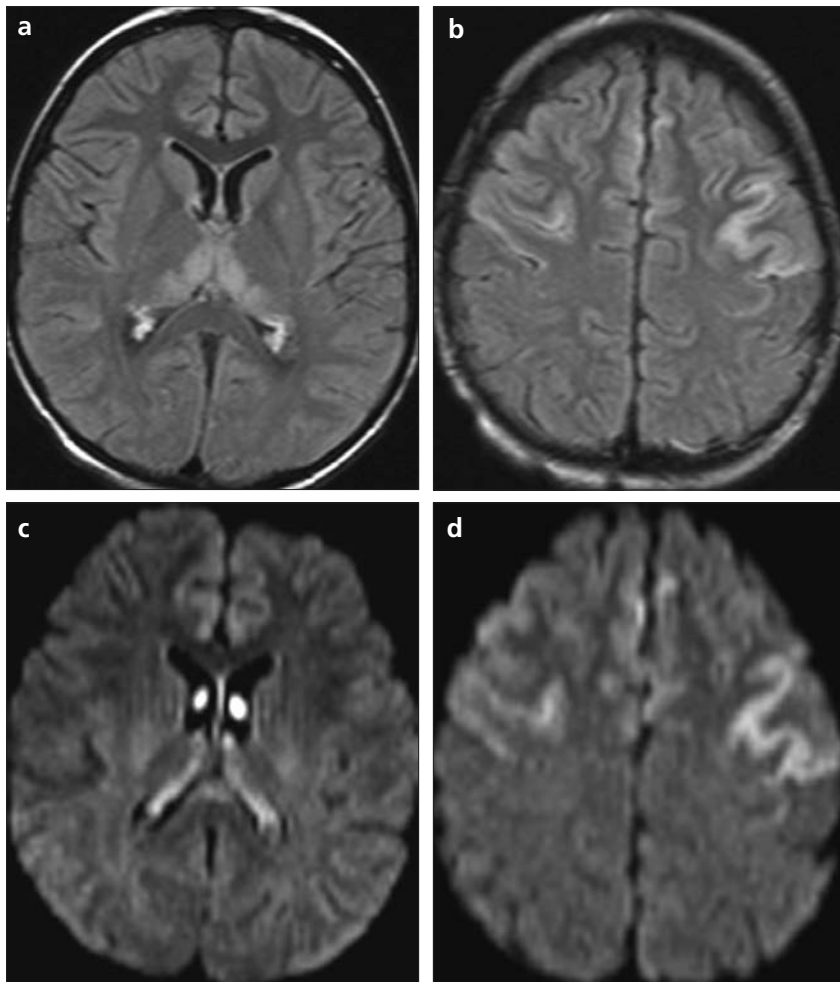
a–d. A 20-year-4-month-old female with acute myelogenous leukemia and posterior reversible leukoencephalopathy syndrome. Cranial MRI shows symmetrical high signal intensities in the bilateral posterior parts of the thalamus, bilateral frontal cortex, and subcortical white matter on axial fluid attenuated inversion recovery (FLAIR) images (a, b). Diffusion weighted MRI (c, d) shows high signal intensity in the areas of FLAIR abnormality. Apparent diffusion coefficient maps showed increased values in the same areas (not shown).
